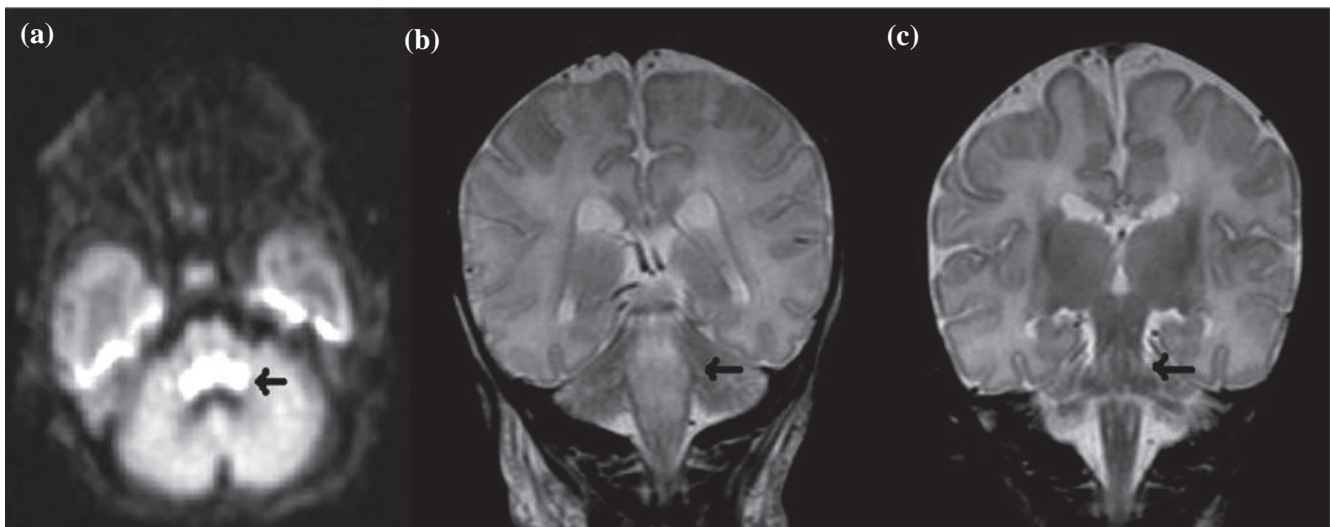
(a) Diffusion-weighted image of MRI on day 3 showing restricted diffusion over the brainstem. (b) Coronal image of MRI on day 3 showing oedematous change in brainstem and upper cervical cord. (c) Coronal image of MRI on day 23 showing gliotic changes in previous oedematous areas.
